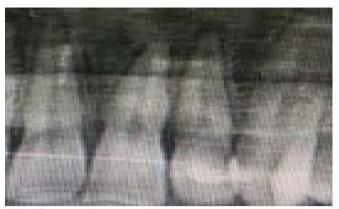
The patient's 1st month radiographic image.
